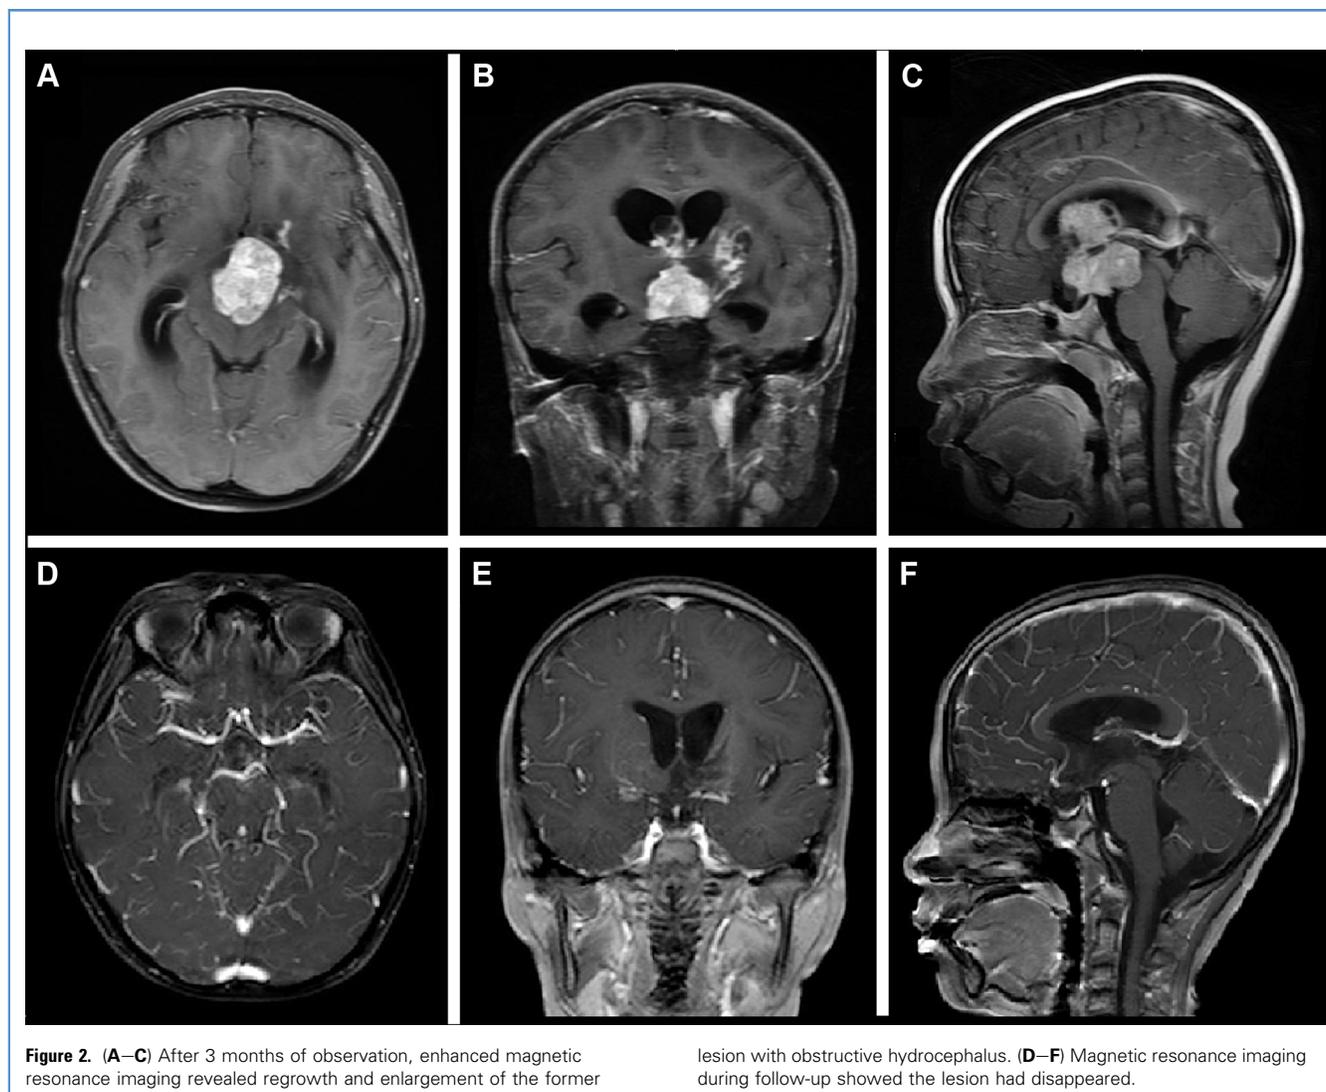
(A–C) After 3 months of observation, enhanced magnetic resonance imaging revealed regrowth and enlargement of the former
